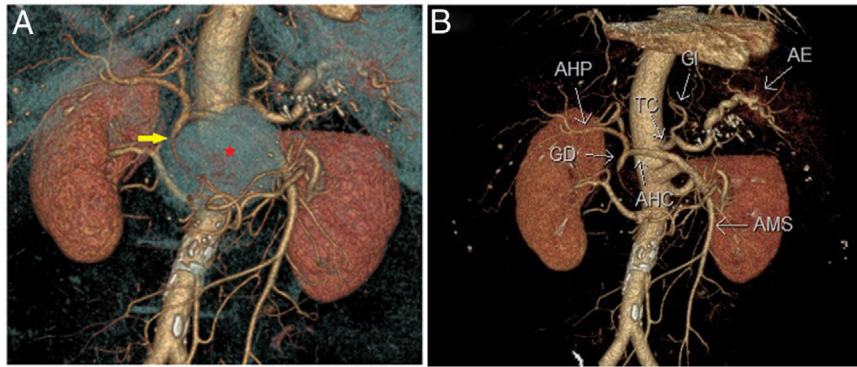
3D reconstruction of the arterial phase. A: poor filling of the pseudoaneurysm (*) due to its large size, causing a change in lumen between the hepatic artery and the outflow of the gastroduodenal artery from which it originates (yellow arrow). B: anatomical variant of the common hepatic artery (CHA) originating from the superior mesenteric artery (SMA), passing to the gastroduodenal artery (GD) and the hepatic artery proper (HAP). Coeliac trunk (CT) with outflow of the left gastric artery (LG) and splenic artery (SA).
